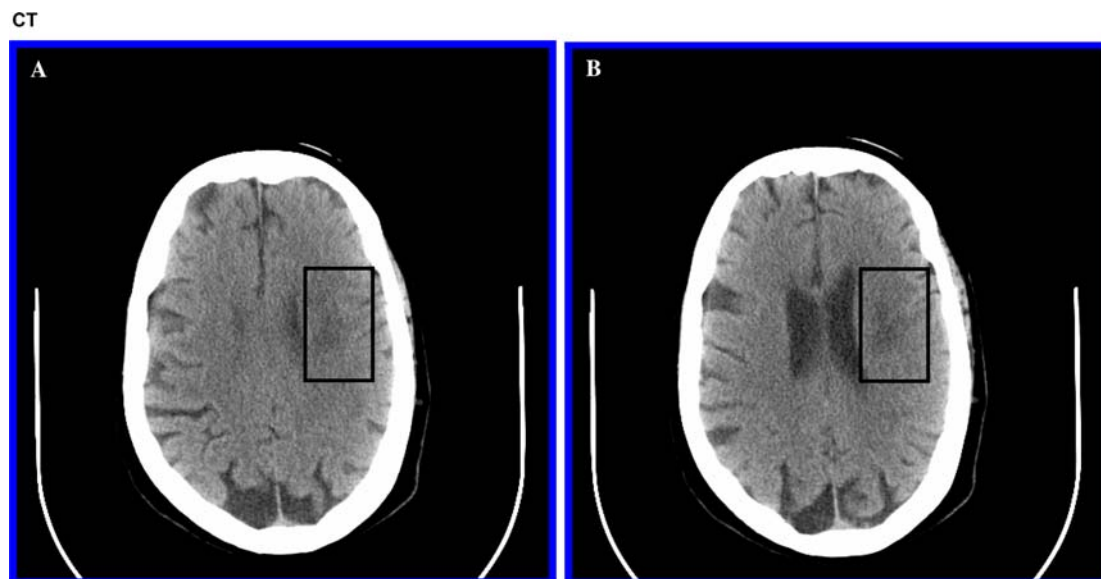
Follow-up CT image of the head, at the 24-h time-point, demonstrates a new 2.2×1.4 cm area of low attenuation in the left periventricular white matter (boxed area)
